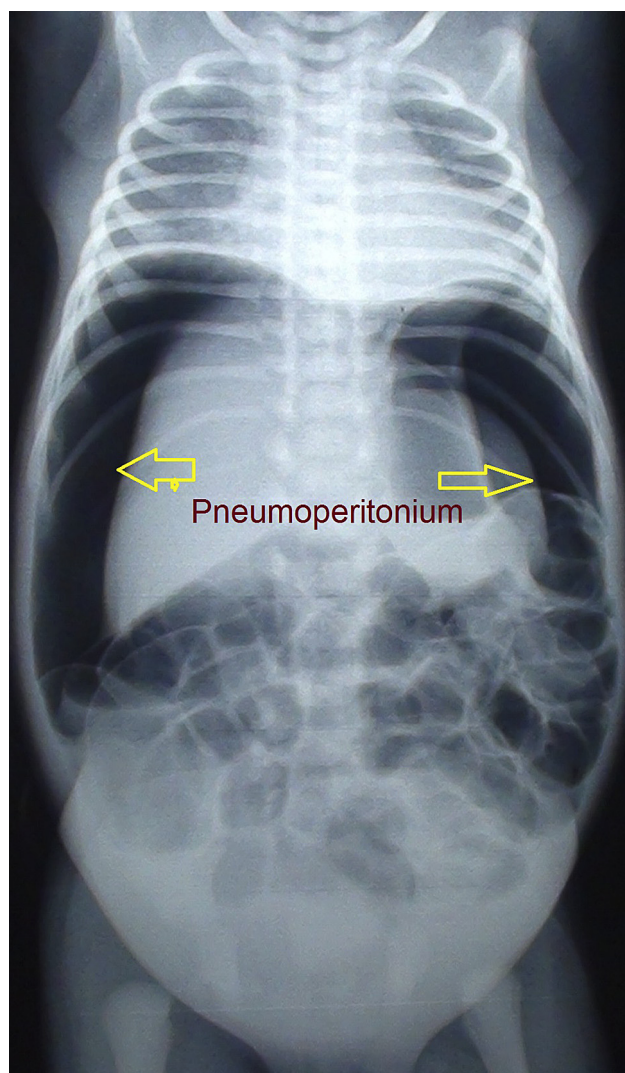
Plain X-ray abdomen showing free gas under both domes of diaphragm suggestive of perforative peritonitis.
